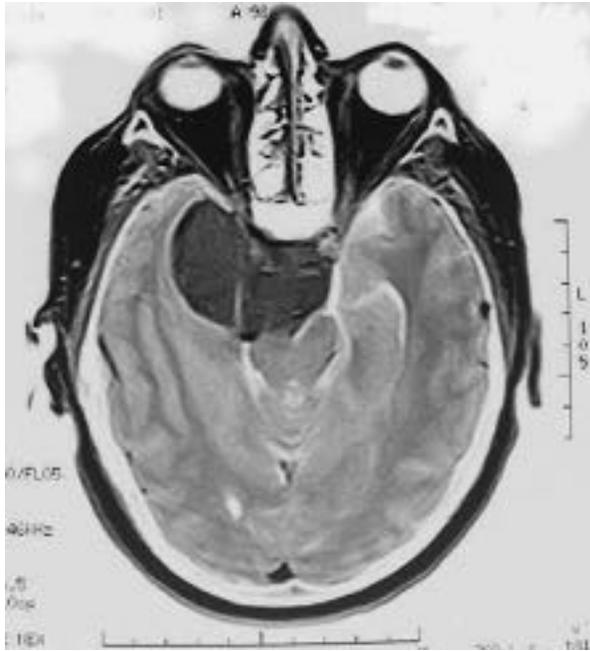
(continued) (C) Axial T1-weighted magnetic resonance imaging of a giant type I clinoidal meningioma engulfing the right internal carotid artery and its branches.
